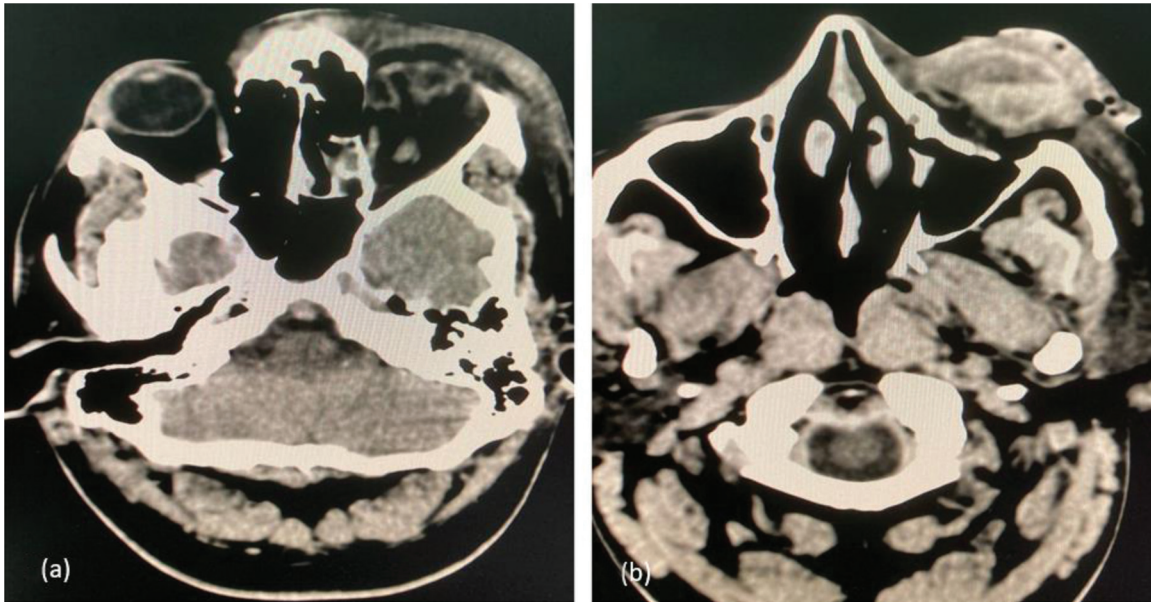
(a) and (b) CT scan axial sections of the brain and orbit showing left expanded globe with displaced eyeball infero-laterally. Intraocular haemorrhage is noted on the left side with no evidence of carotid-cavernous fistula.
